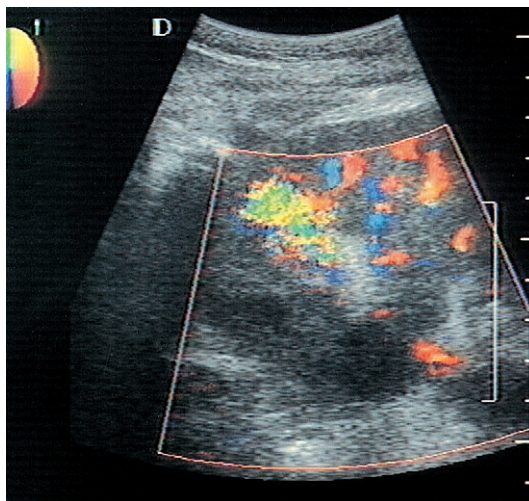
Arteriovenous fistula. Colour flow Doppler demonstrates increased focal flow within the kidney, with a tissue bruit of colour out with the renal vessels caused by vibration of the adjacent renal substance.
